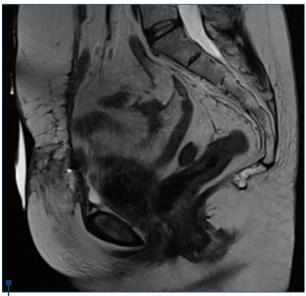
Postoperative MRI aspect
